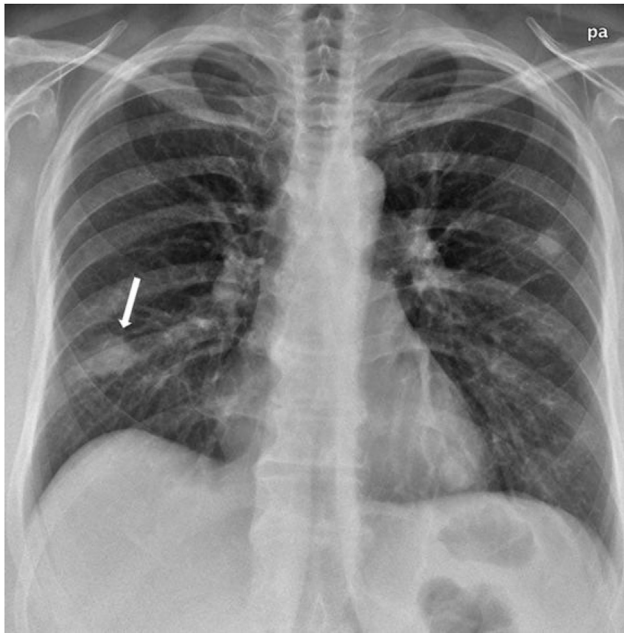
Follow up chest radiograph (posteroanterior view) performed following treatment, demonstrates significant decrease in size of largest lesion in mid lung zone (white arrow).
